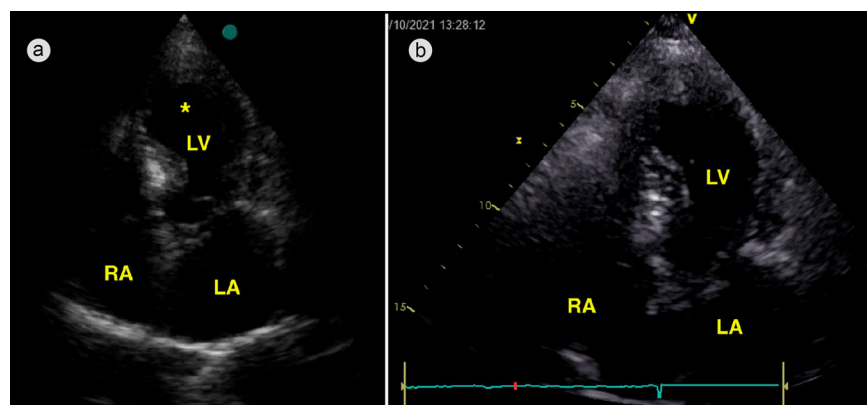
Echocardiography, apical four-chamber view (a) on presentation, showing apical ballooning (yellow asterisk) and (b) 72 hours after presentation, showing a significant decrease in the apical ballooning. LA indicates left atrium; LV, left ventricle; RA, right atrium.
